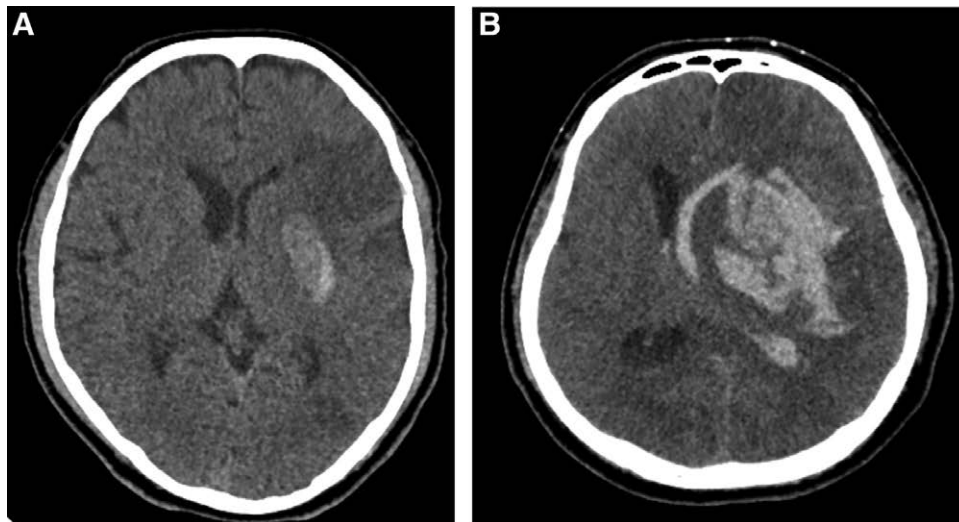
Representative images of (A) asymptomatic intracranial hemorrhage (ICH) and (B) symptomatic ICH on axial computed tomography (CT) scans. (A) CT scan demonstrating ICH of left putamen without additional neurological deterioration, classified hemorrhagic infarction type 2 according to ECASS criteria. (B) CT scan showing ICH of left basal ganglia with intraventricular hemorrhage and mass effect causing a midline shift to the right (ECASS criteria parenchymal hematoma type 2), leading to clinical deterioration. ECASS, European Cooperative Acute Stroke Study.
